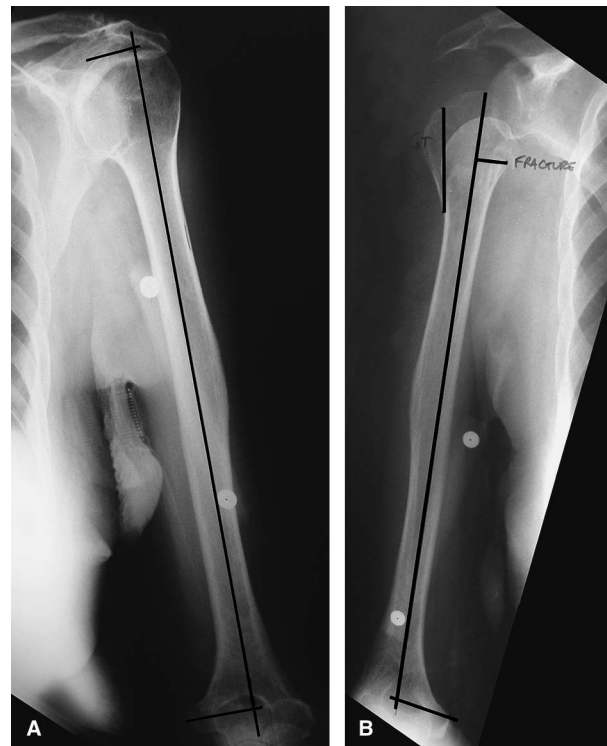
A, Scaled radiograph of normal humerus. B, Scaled radiograph of injured humerus.
